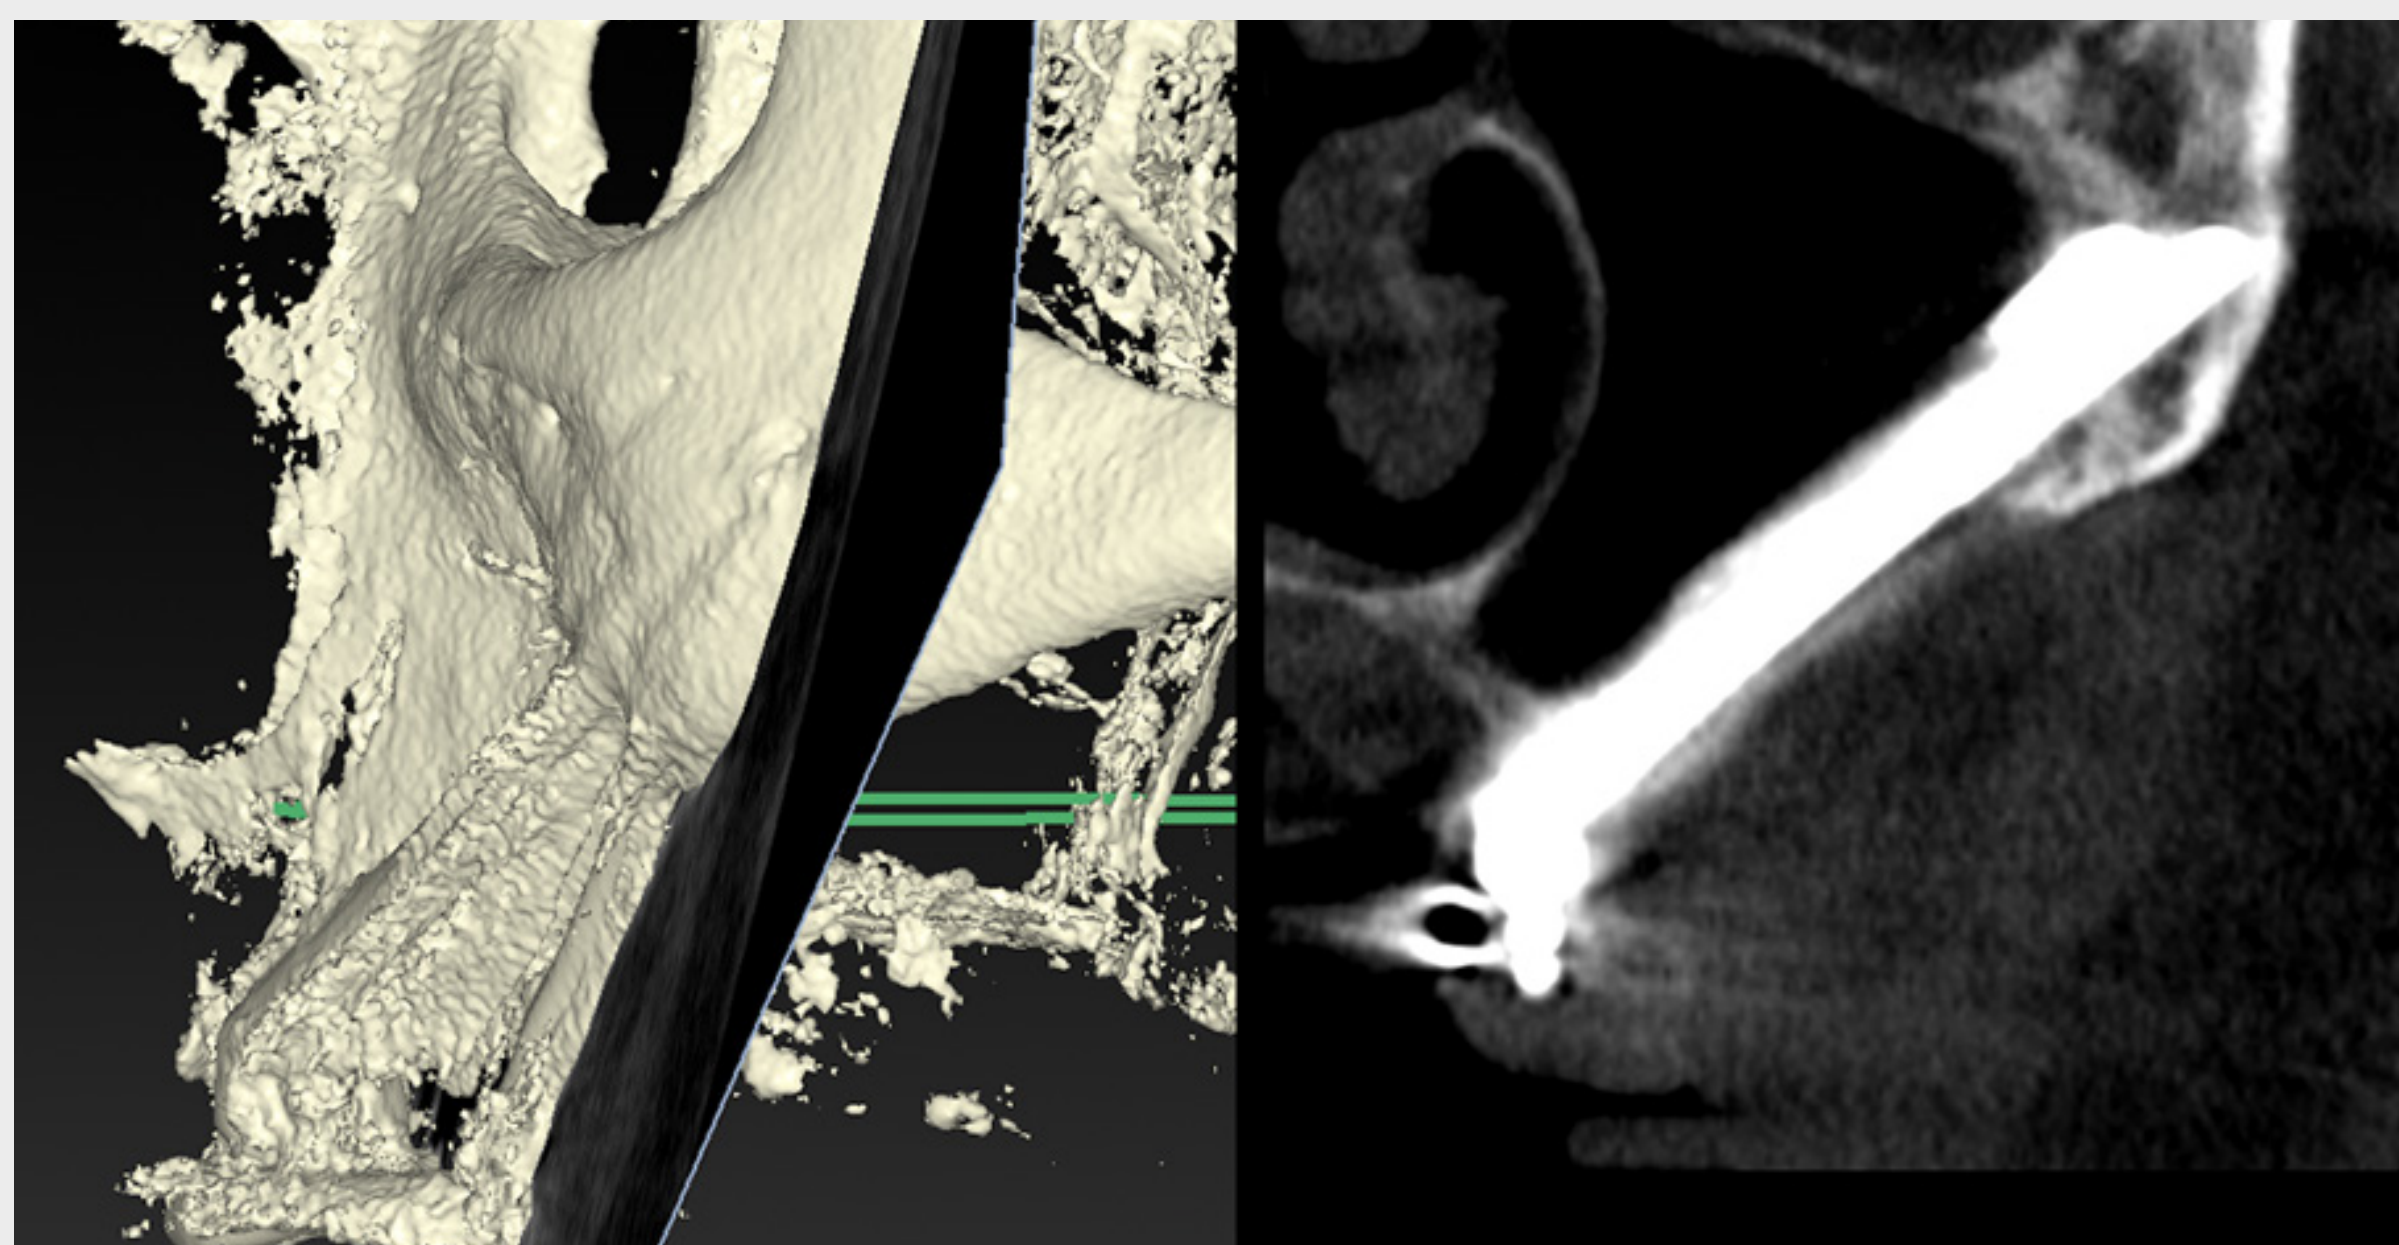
CBCT cut through the posterior left implant (ZAGA™ Type 4 - Straumann® Zygomatic implant, ZAGA™Flat,) showing the transparency of the maxillary sinus after one year. Compare with the pre-surgery status shown in figure 4d.
